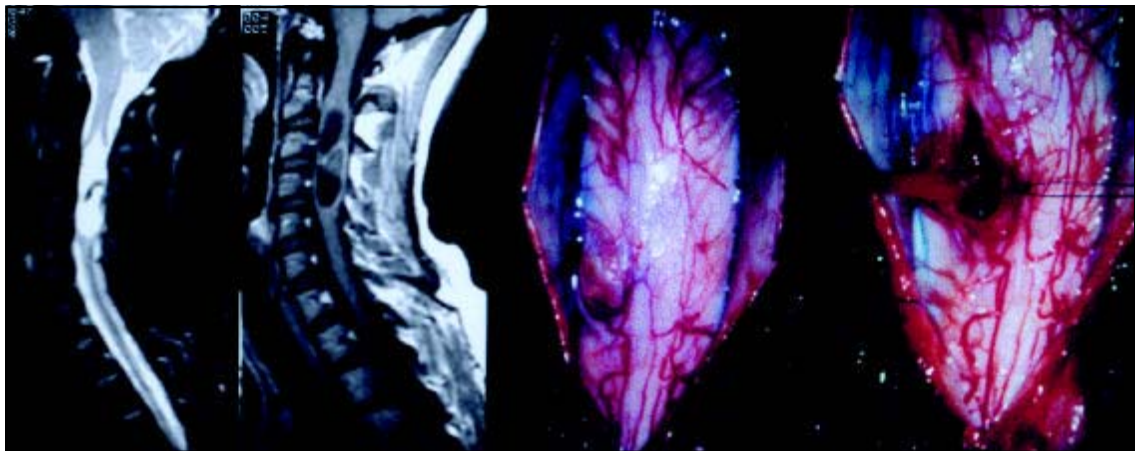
MRI Sagittal T2WI and Sagittal T1WI: Intramedullary cystic lesions and pictures of the surgical removal of them.
